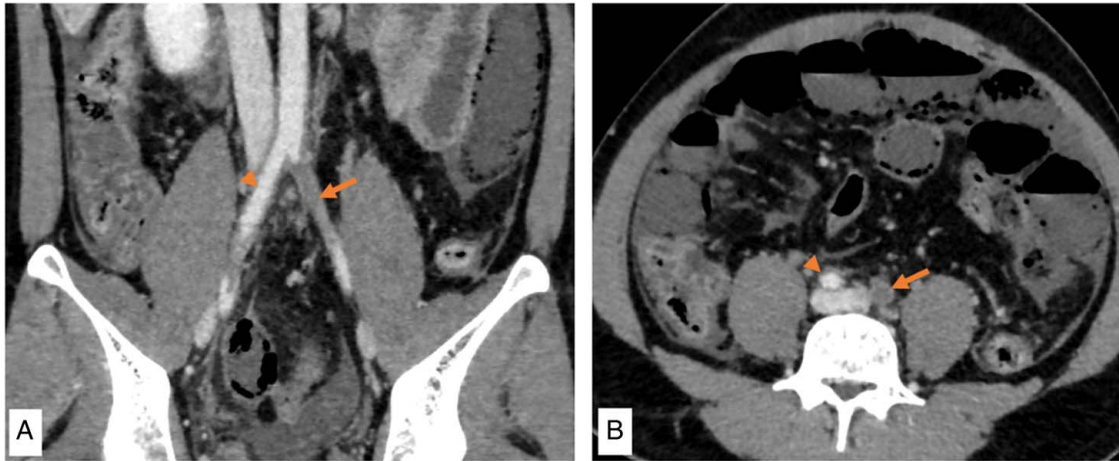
Contrast-enhanced computed tomography images of the abdominopelvic region in coronal plane (A) and axial plane (B) show nonenhancing filling defect in the proximal part of the left common iliac artery (orange arrow) suggestive of 'thrombosis,' starting just distal to the aortic bifurcation. The presence of pneumatosis intestinalis is also demonstrated as described in previous images. Orange arrowhead: normal opacification of the right common iliac artery.
